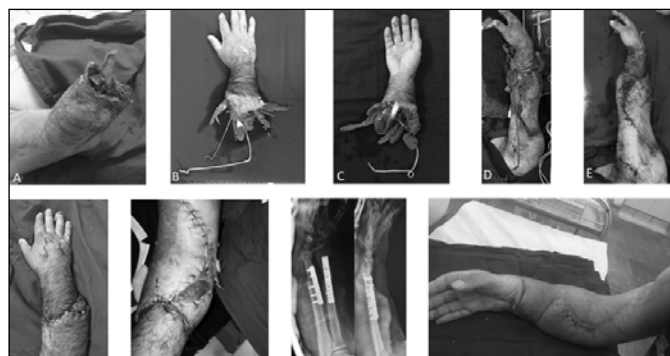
Case 2: (A, B, and C) Upper limb and amputated forearm; (D and E) Intraoperative images; (F and G) Appearance after one week of surgery; (H) Forearm X-ray after conversion for synthesis with a screw plate; (I) Aspect of the upper limb at follow-up.
